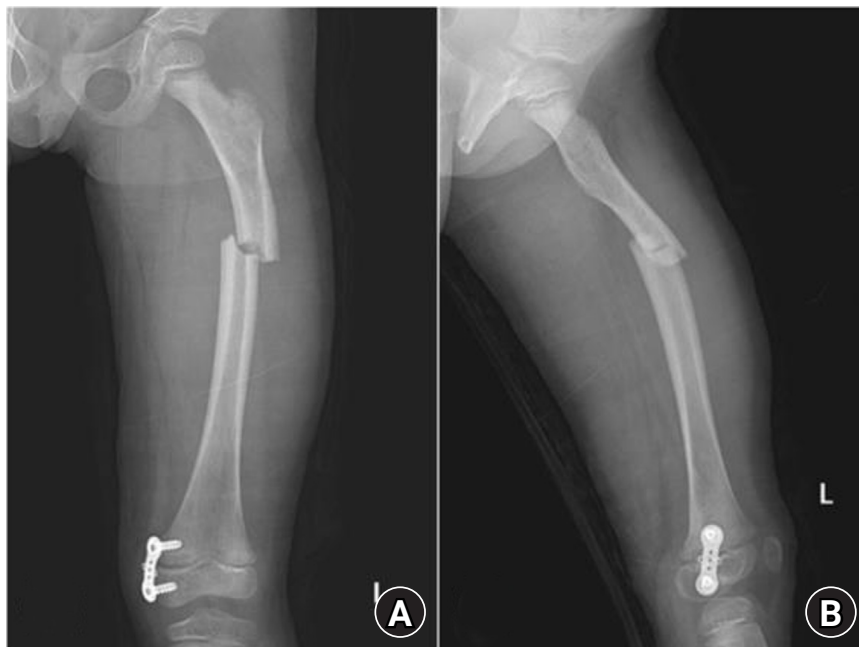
Radiographs of the same patient with a proximal one-third fracture of the left femur. (A) Anteroposterior view. (B) Lateral view.
